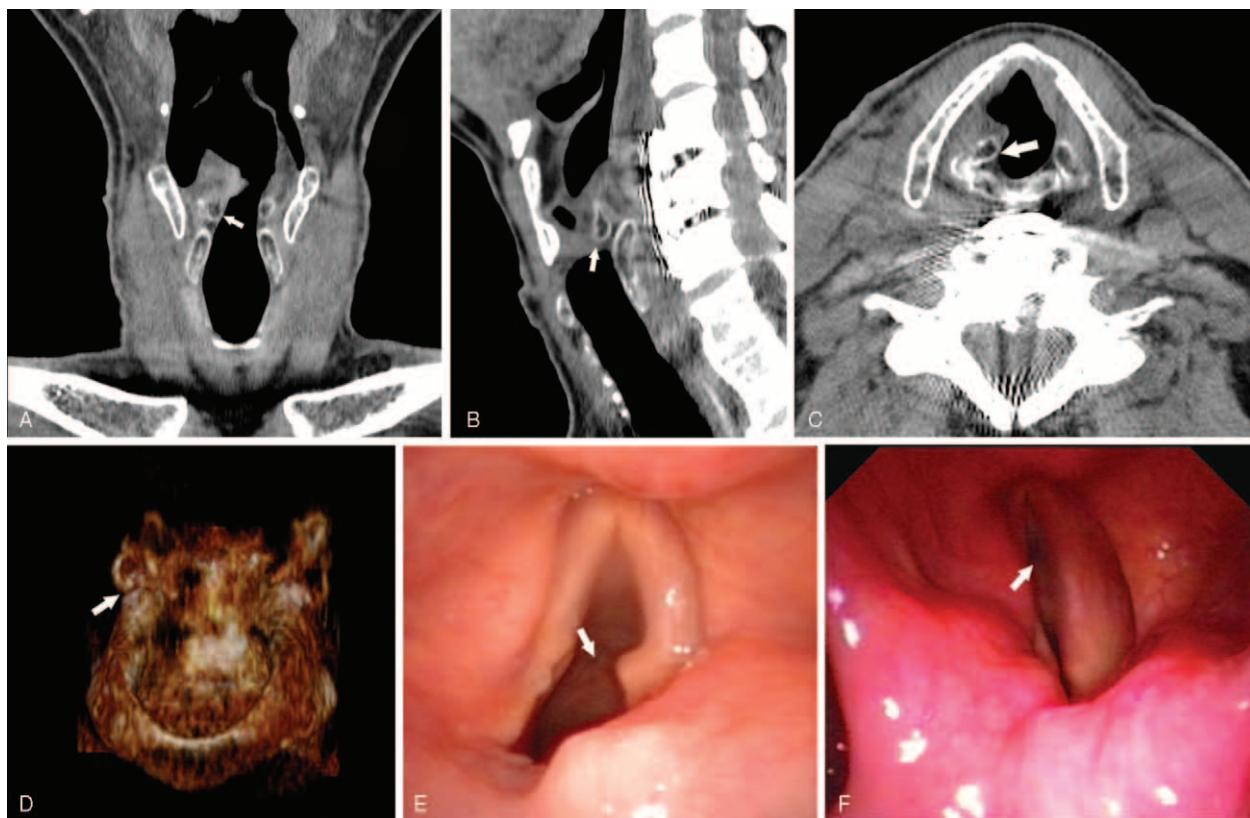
A: Coronal images of high-resolution CT scanning shows dislocation of the right arytenoid cartilage inward. (As shown in the white arrow). B: Sagittal images of high-resolution CT scanning shows dislocation of the right arytenoid cartilage forward. (As shown in the white arrow). C: Axial images of high-resolution CT scanning shows dislocation of the right arytenoid cartilage in front inward shift. (As shown in the white arrow). D: Three-dimensional CT view shows asymmetry in the joint space with a wider space on the right(As shown in the white arrow). E: Laryngoscopic view shows poor mobility of the right vocal fold(As shown in the white arrow). F: Laryngoscopic view shows incompetent glottal closure of the right vocal fold (As shown in the white arrow).
